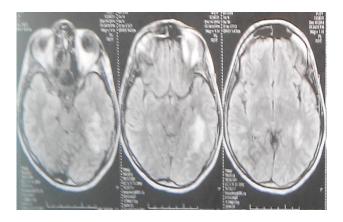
MRI brain showing glioma in left posterior temporal sub-cortical white matter.
